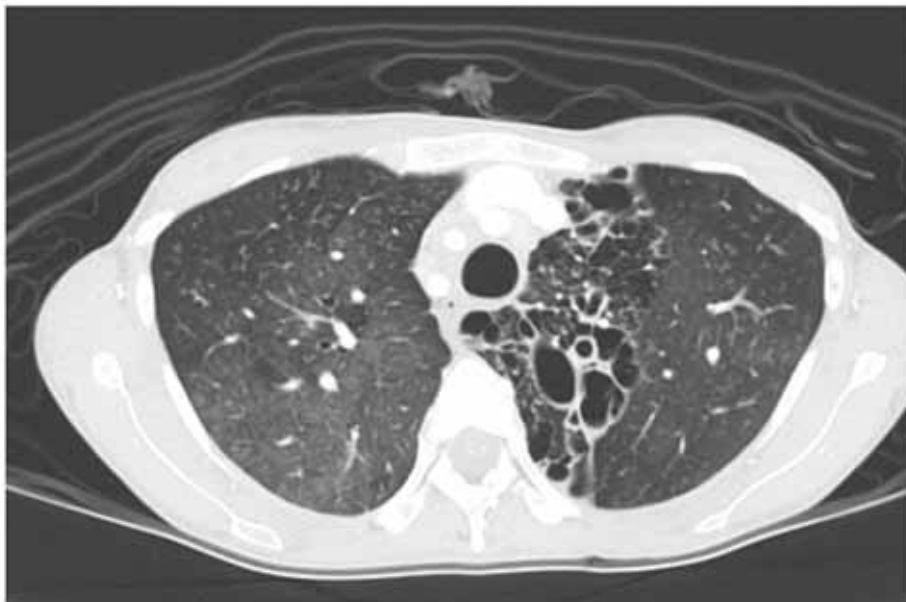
CT of the chest (axial view and lung window) There were cystic bronchiectasis at LUL.
